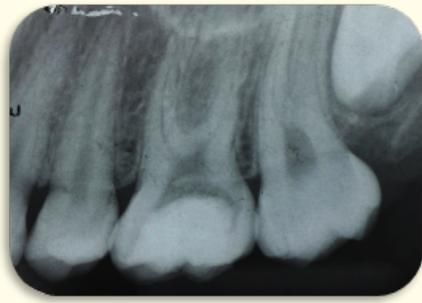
Radiographic exam after restoration.
